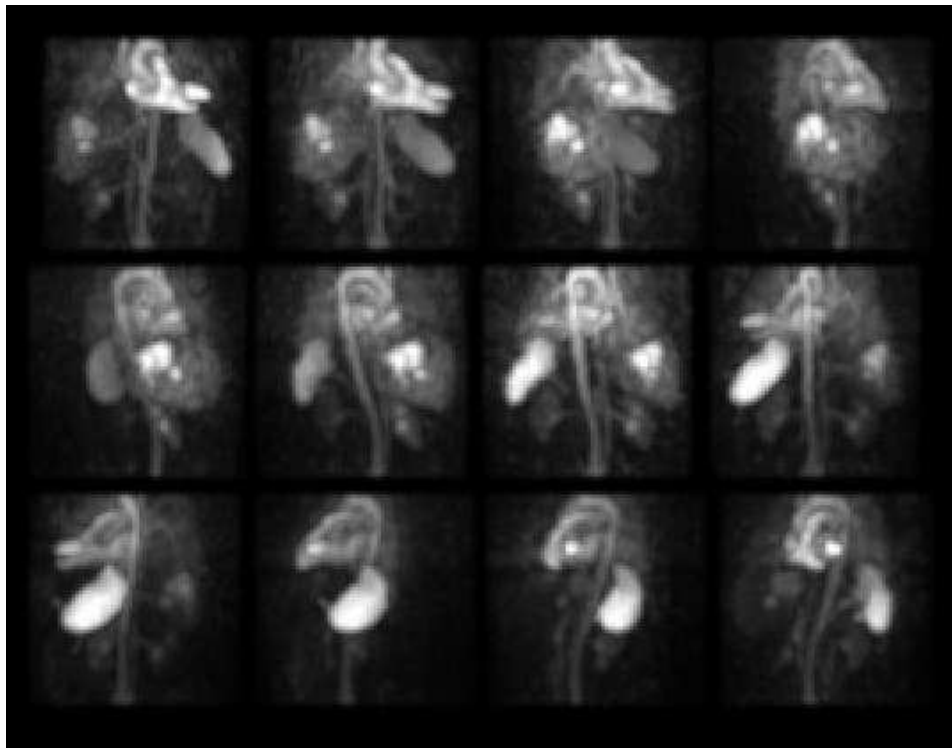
Projections by SPECT Imaging. (Wang and Royal, 1996)
